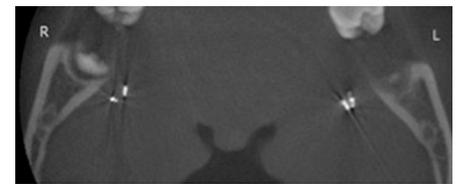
CBCT image – Axial view showing metallic objects medial to the mandibular rami bilaterally
